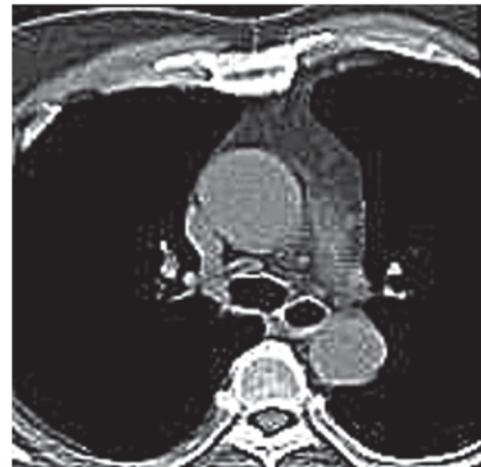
Unenhanced CT image of a male myasthenia gravis patient (age, 59 years) with normal (involved) thymus. The thymus is quadrilateral in shape and homogeneous regarding CT attenuation. CT, computed tomography.
